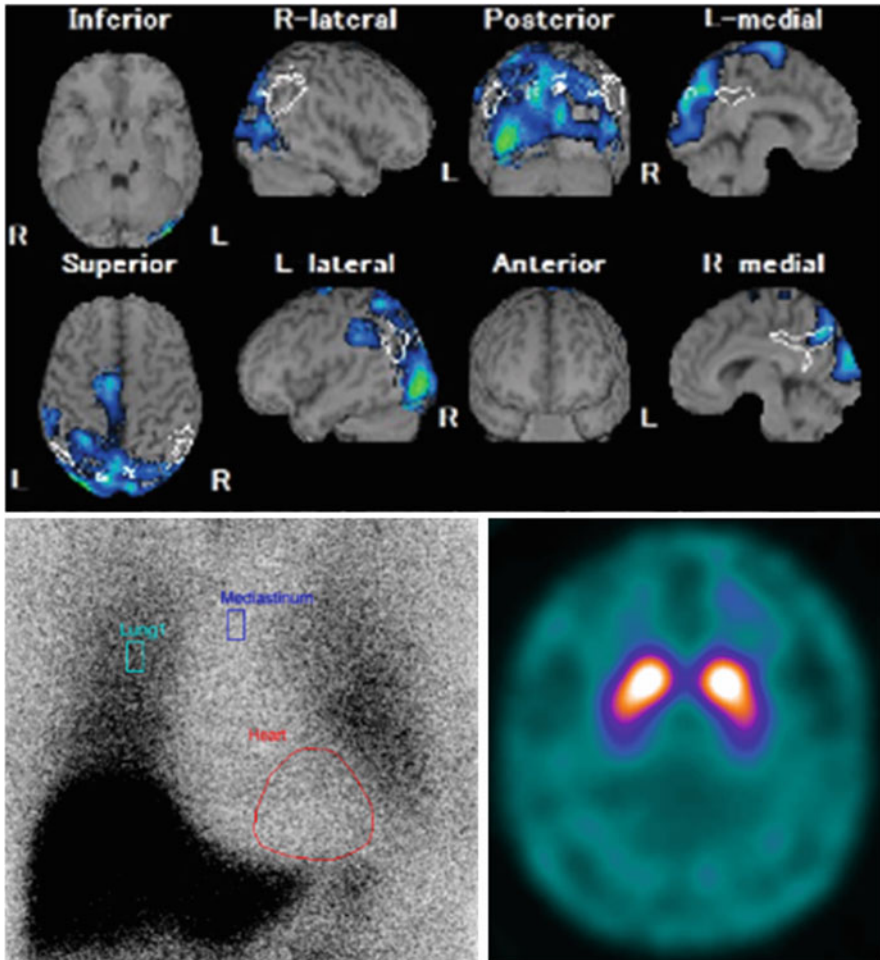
Figure 16.3 showed 80 patients with prodromal DLB patient. He complained visual hallucination, but parkinsonism and cognitive decline were not observed. Brain SPECT imaging showed occipital hypoperfusion. Accumulation of cardiac MIBG scintigraphy was significantly decreased. However, FP-CIT finding was normal. After 2 years, he showed cognitive decline and fulfilled diagnostic criteria of probable DLB
